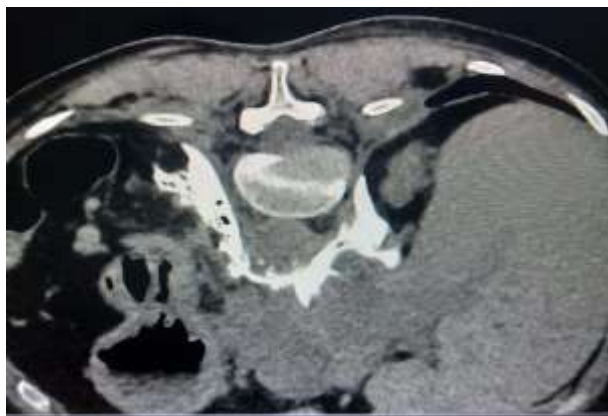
Axial CT scan image showing final image with mixture of absolute alcohol, contrast and bupivacaine outlining aorta, coeliac artery origin and crura of diaphragm.
